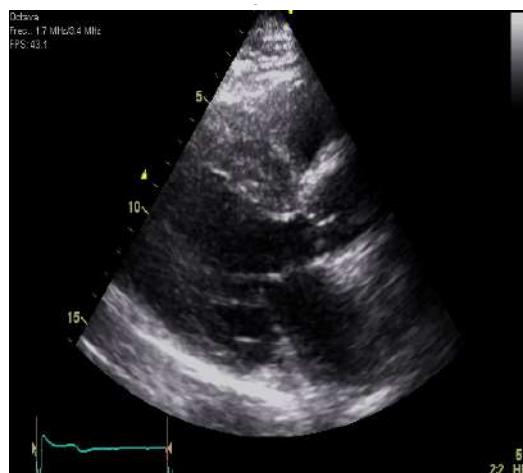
A parasternal long-axis view of a patient with septal HCM. Note the marked increase in septal wall thickness and the asymmetry compared to the posterior wall.
